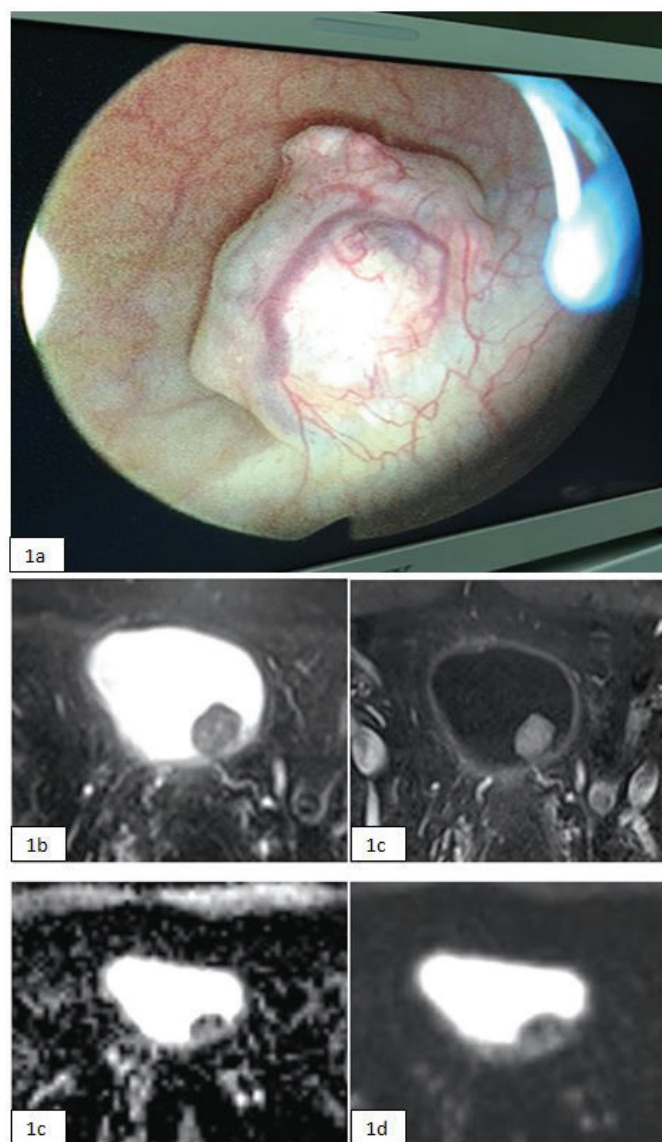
Macroscopic image of the tumor (a), Contrast enhanced T2-weighted transvers MRI image (b), Contrast enhanced T1-weighted transvers MRI image (c), ADC map and diffusion-weighted MRI image (d, e).
